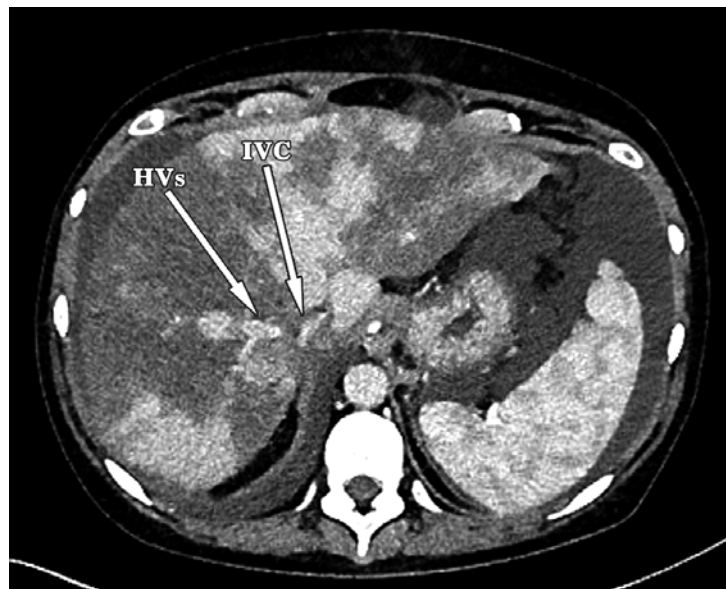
Computed tomography scan of abdominal organs. Signs of congestive abnormalities in the liver are manifested by diffuse heterogeneous mottling appearance of the liver parenchyma, narrowed hepatic veins and the inferior vena cava at the level of the intrahepatic section (indicated by white arrows)
